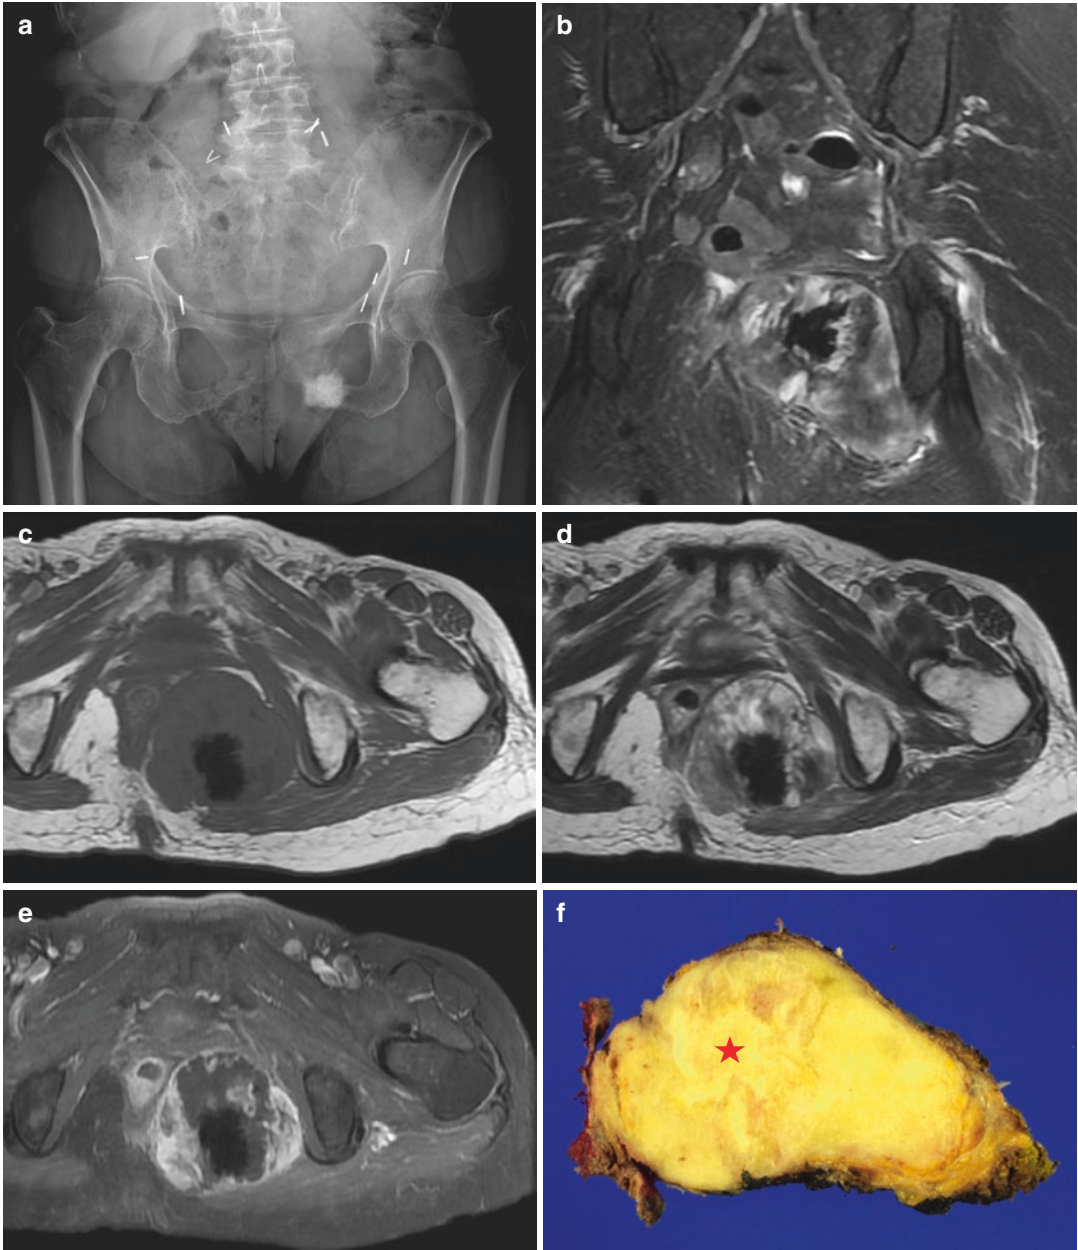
Extraskelletal osteosarcoma. A patient underwent a total abdominal hysterectomy of a cervical cancer, followed by a course of radiation therapy 27 years ago. She presented with left pelvic pain 3 weeks ago. Pelvis radiograph (a) shows a multilobulated, multinodular dense calcification with some speculated margin adjacent to left ischium. Coronal FS T2WI (b) shows a large soft tissue mass in left ischio-rectal fossa, medial to left
